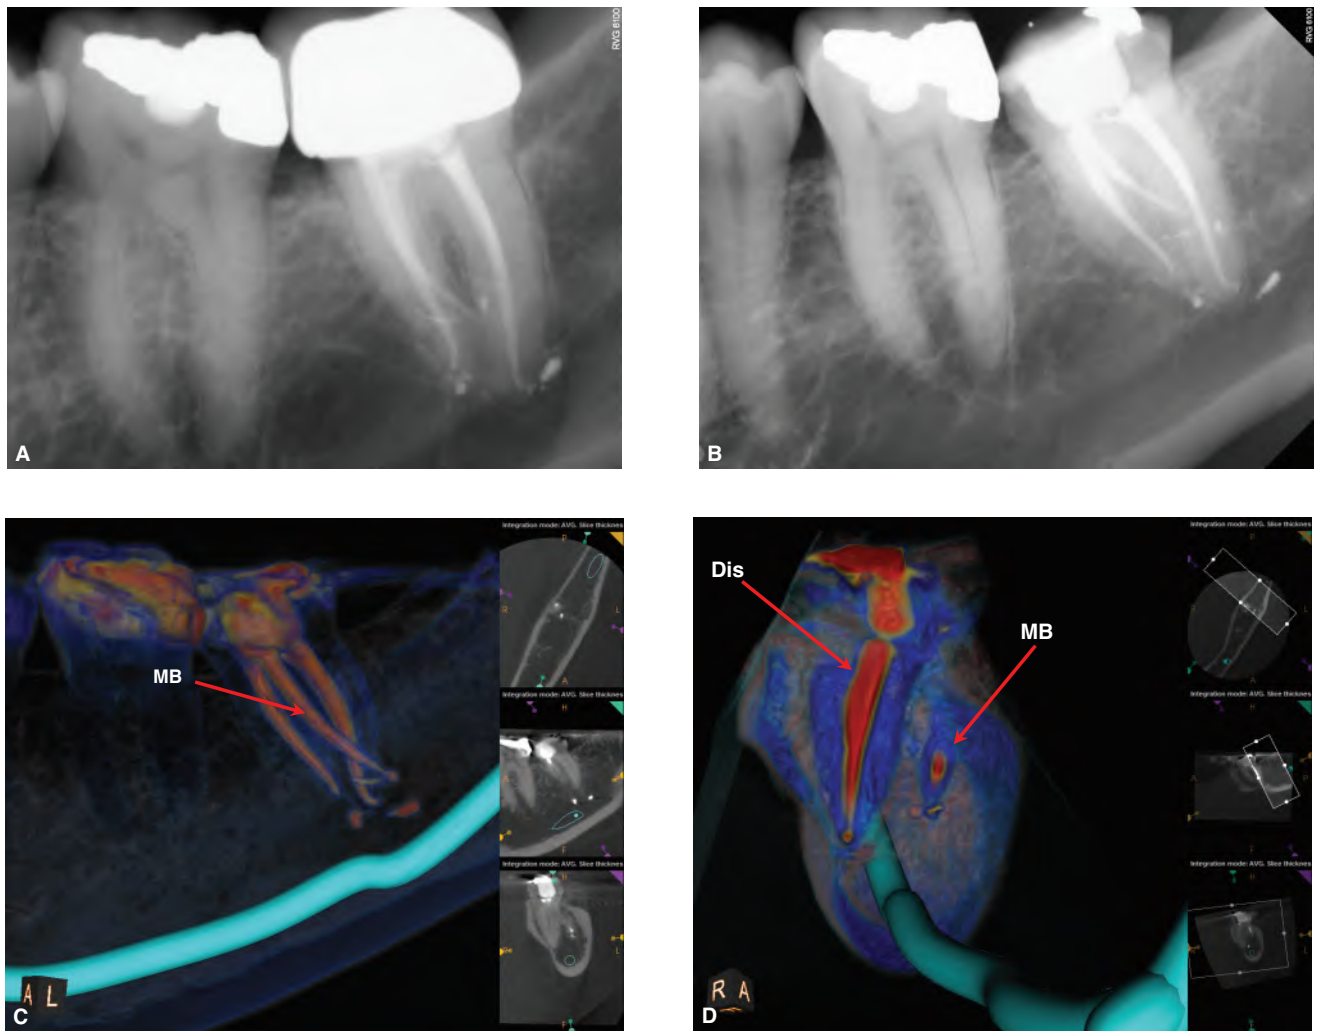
The inability to accurately assess the clinical environment with conventional radiographs is dramatically demonstrated in this case series. The patient presents with the chief complaint of sensitivity to biting, the onset being the completion of the endodontic treatment. A clinical examination revealed no evidence of deep periodontal probing or vertical fracture, and percussion and palpation findings were within normal limits. A. Postoperative radiograph from 2011 reveals the presence of several small extrusions of sealer from the apices of the mandibular left second molar. B. Radiograph taken prior to the patient receiving a new crown in 2014. The extruded material has not resorbed. C. The MB root is a separate root, coursing more distal and buccal than the main root form. There is no overt periapical pathology, but small extrusions of material are present. The material is not in the mandibular canal. Any foreign body is ordinarily removed via curettage, but the overlying bone thickness measures 11.5 mm to the distal root apex (nearly one-half inch). D. The excavation would be further complicated by the location of the MB root centered in the proposed osteotomy, itself 5.5 mm below the surface of the cortical plate. Access to the periapical extrusions could be realized during an IR procedure, but the atypical root anatomy presents a considerable challenge to an atraumatic extraction, and needs to be addressed during the informed consent.
